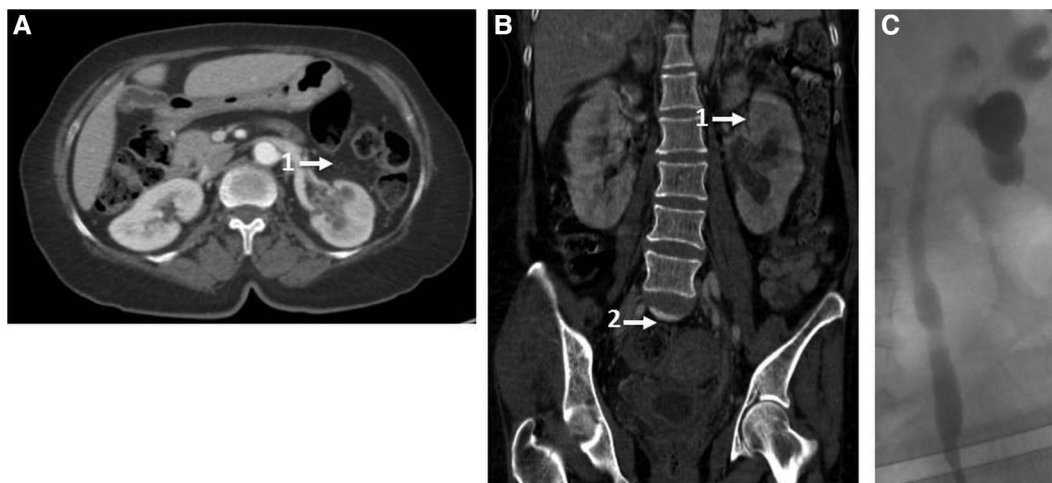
CT of the abdomen and pelvis (A and B) demonstrating moderate left hydronephrosis (arrow 1) and a thickened bladder wall (arrow 2). Left retrograde pyelogram (C) demonstrating a moderately dilated left pelvic calyceal system with a long stricture of the distal left ureter.
